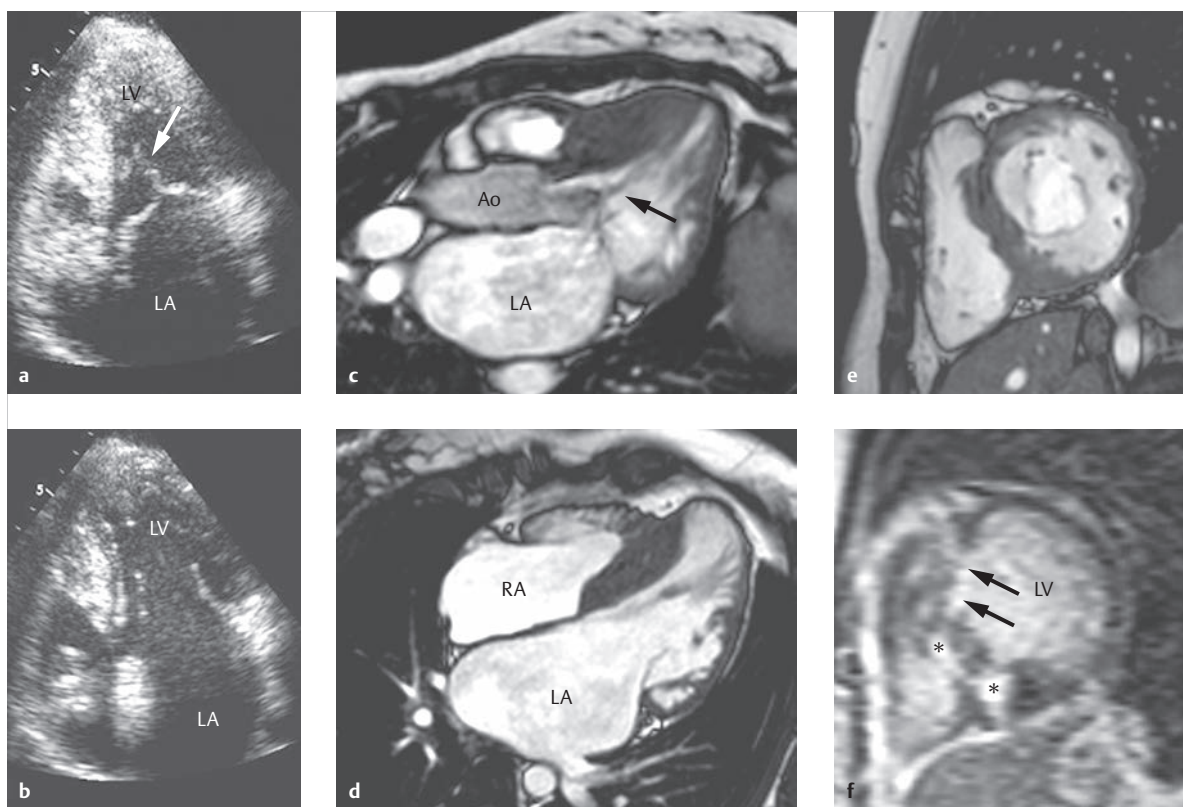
Condition after two myectomies and transcatheter ablation of septal hypertrophy in a case of HOCM. Twenty-three-year-old woman with HOCM. Both the echocardiography (a, b) and MRIs of the LVOT (c) and MRI, 4-chamber view (d) depict a massively enlarged left atrium due to the formerly pronounced mitral valve insufficiency. The maximum flow velocity in the LVOT was measured at $V_{max} = 2.1$ m/s using the MR phase contrast technique and CW Doppler, suggesting a small residual gradient. The anterior septal segments of the late enhancement (f) are caused by the therapeutically intended scar formation due to myectomy and septal ablation (arrows). The other patchwork-like, diffuse septal fibrosis (asterisk) is a part of the typical late enhancement pattern of HCM.
